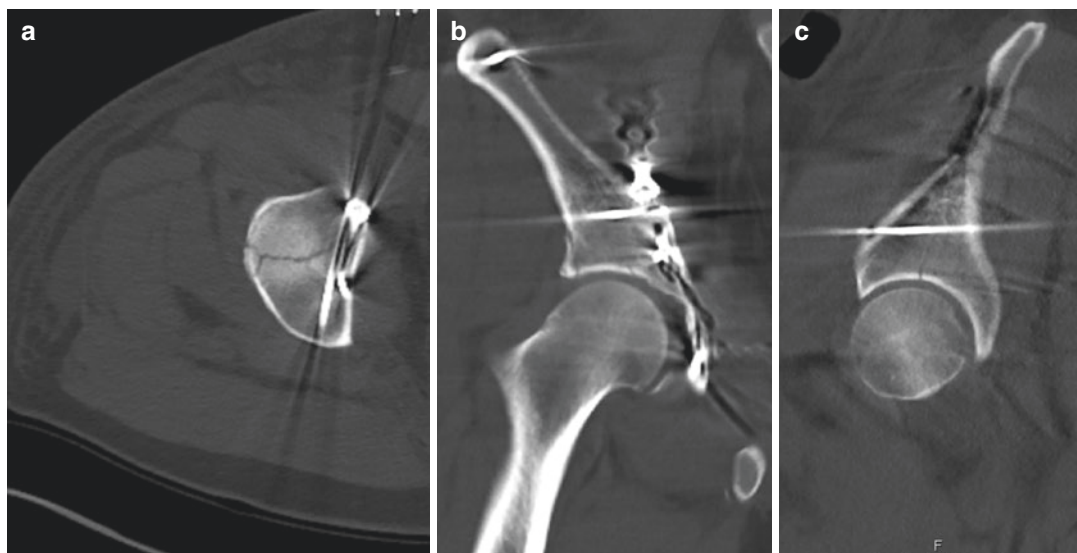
The postoperative CT scan shows anatomical reduction of the fractures in the axial (a), coronal (b), and sagittal (c) planes. Compared to Fig. 4.9, the fracture lines are anatomically reduced
